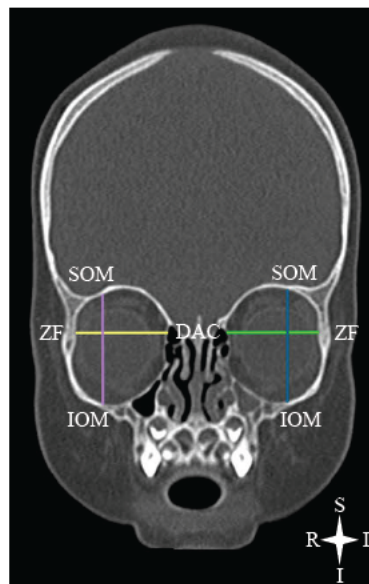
Orbital measurements on a coronal CT scan of a normal patient (height: IOM to SOM; width: ZF to DAC). Key: IOM – inferior orbital margin; SOM – superior orbital margin; ZF – zygomaticofrontal suture; DAC – dacryon
